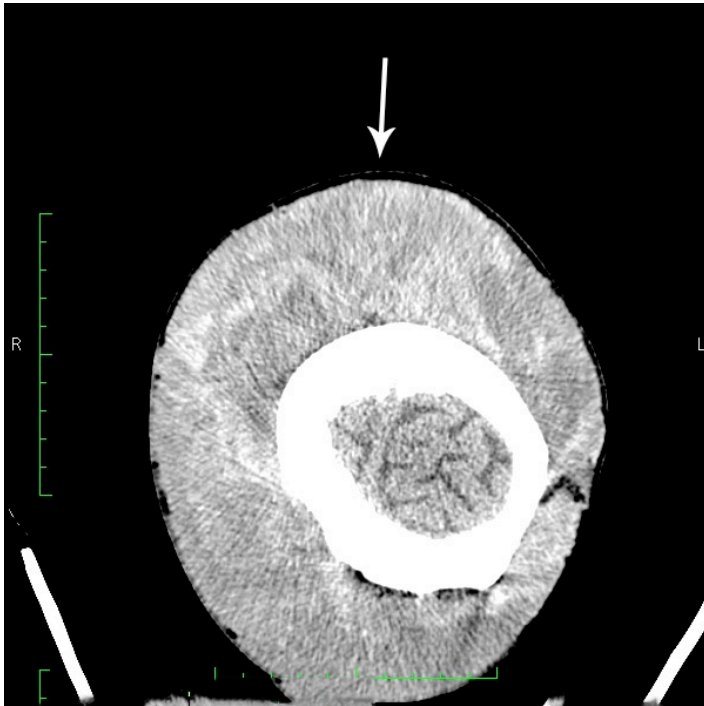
Computed tomography demonstrating extensive cephalohematoma in the soft tissues of the scalp.
